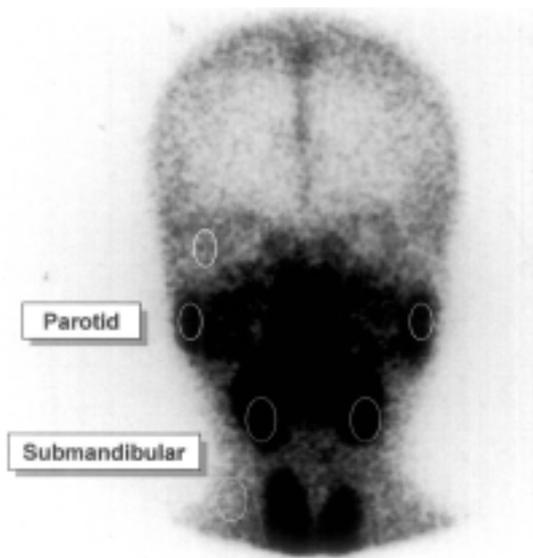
Regions of interest in scintigraphic image.
